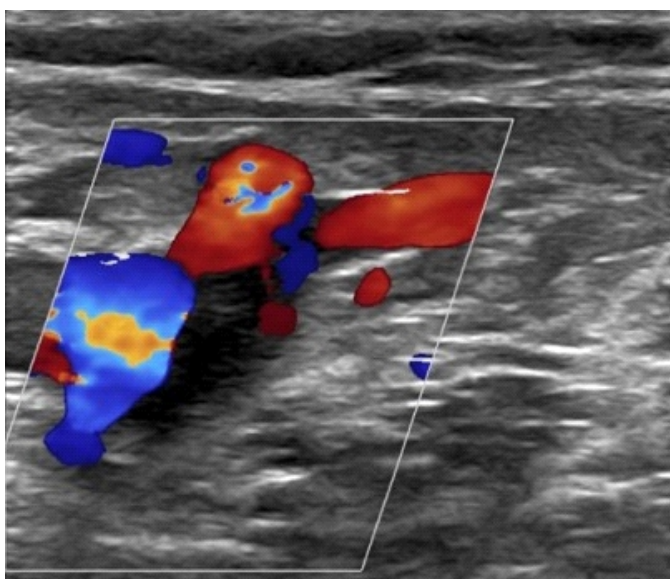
Venous Doppler of right leg shows persistent partial thrombus at the saphenofemoral junction.
